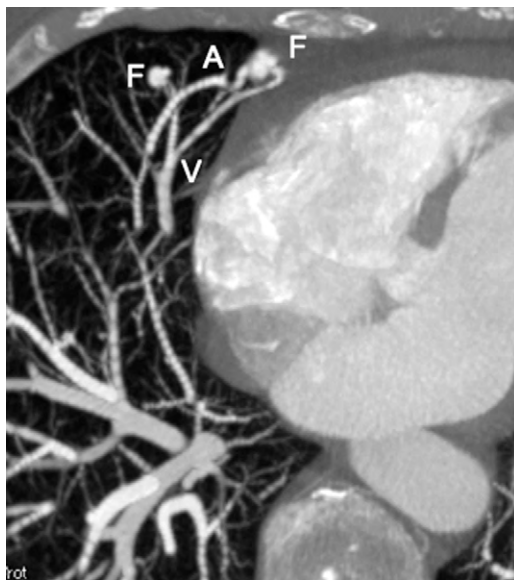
Computed tomogram of the chest in maximum intensity projection; axial reconstruction, showing the presence of 2 fistulas. A: artery, F: fistula, and V: vein.
